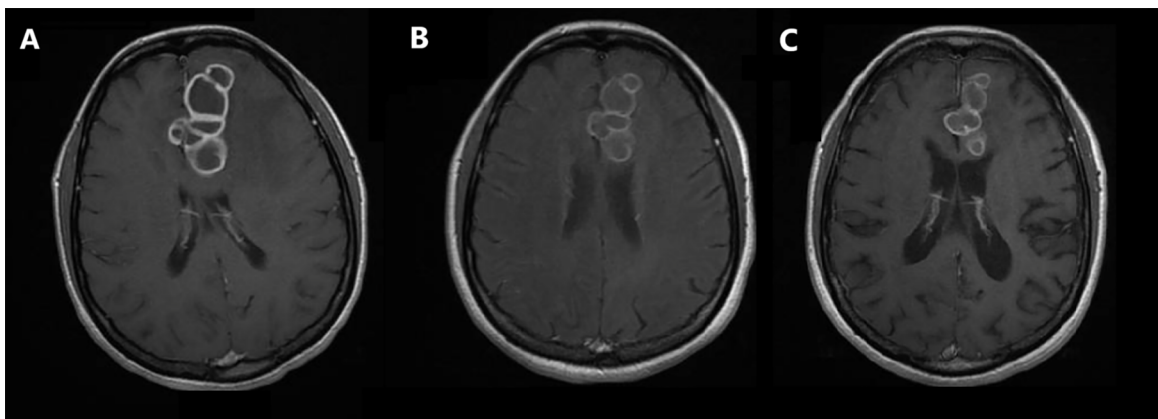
T1-weighted magnetic resonance imaging (MRI) in post-gadolinium axial slices). 1A- MRI performed at the time of hospitalization (after 90 days of ART and 60 days of RHZE); 1B- another exam performed after 120 days of RHZE; 1C – the last MRI performed on an outpatient basis, after almost 2 years.
